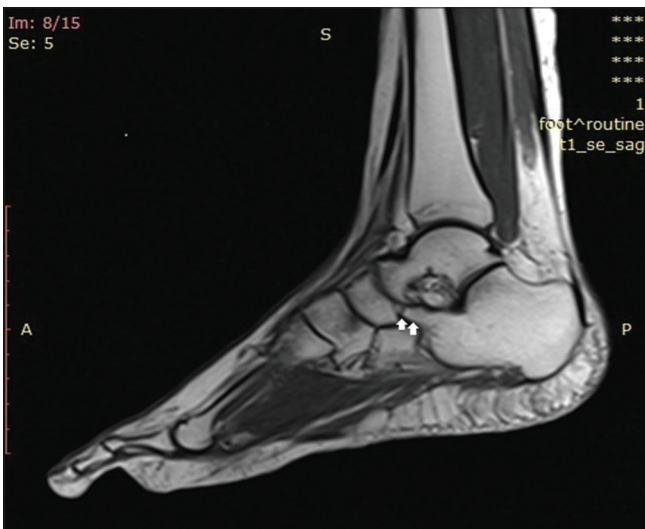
A sagittal T1-weighted magnetic resonance image of a 22-year-old female complaining of the right heel pain demonstrates the osteocartilaginous type of calcaneonavicular coalition where an elongated anterior process of the calcaneus (arrowheads) approaches the navicular, sometimes referred to as the “anteater’s nose sign.”
